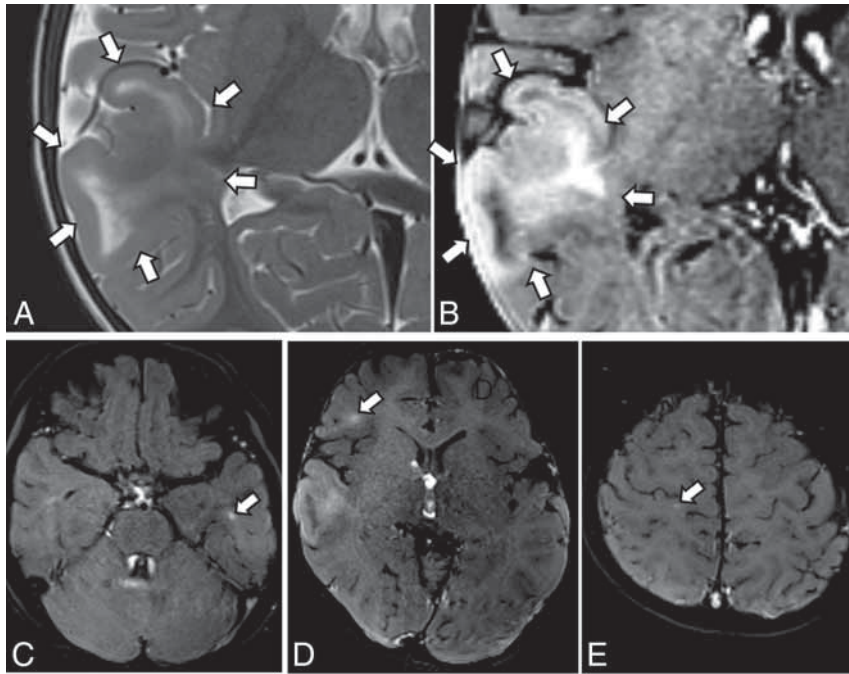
MR imaging findings of the surgical case, a 20-month-old boy with repeat epileptic seizures. A, Axial T2WI shows swelling of the cortex and subcortical hyperintensity (arrows), consistent with a cortical tuber. No other lesions are noted on T1WI, T2WI, and FLAIR (not shown); suggesting focal cortical dysplasia or a solitary cortical tuber. B, Axial T1WI-CHES shows marked hyperintensity in the swollen cortex and subcortical white matter (arrows). C–E, Axial T1WI-CHES shows several RMLs as linear hyperintense areas (arrows). On the basis of these findings, the patient was diagnosed with TSC.
